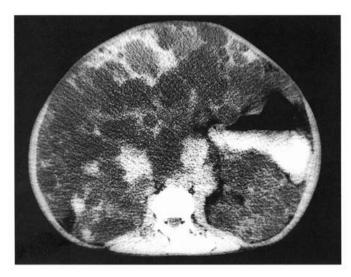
Computed tomographic scan in our patient showing diffuse PCLD without areas of significant parenchymal sparing. Note the presence of polycystic disease in the bilateral kidney
